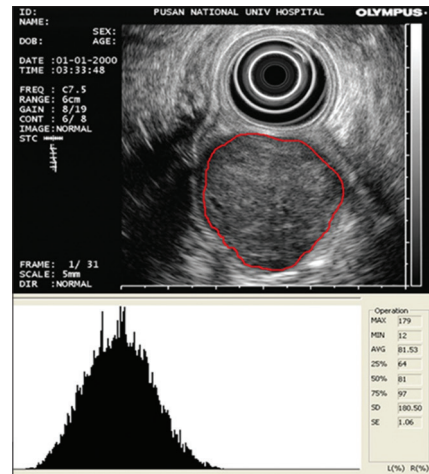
The scope of the tumor is indicated by the red outline in the upper endoscopic ultrasonography image.^[4] A digital image analysis system was then used to calculate T_{mean} and T_{SD} in order to determine whether the tumor constituted a gastrointestinal stromal tumor
